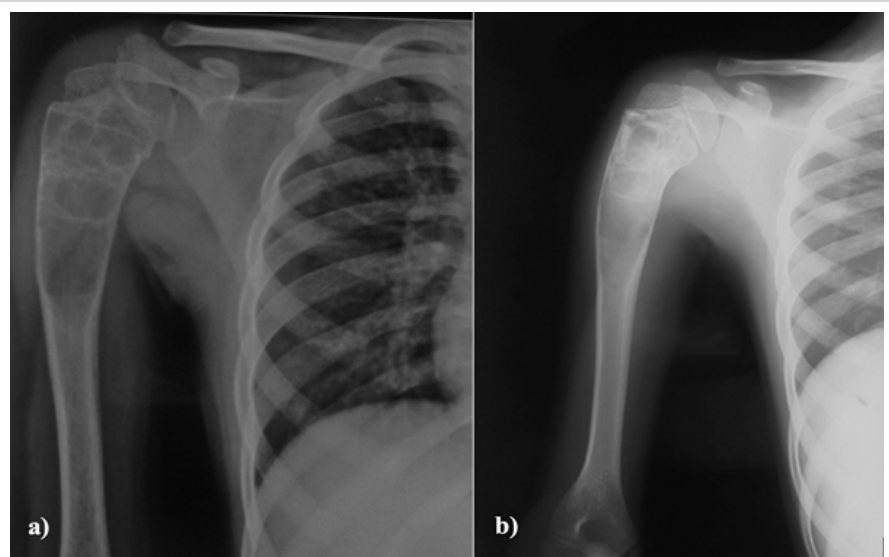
Radiograph of 12 year old female aneurysmal bone cyst of the proximal humerus a) showing pathological fracture b) showing partial healing of the cyst with fracture healing.
